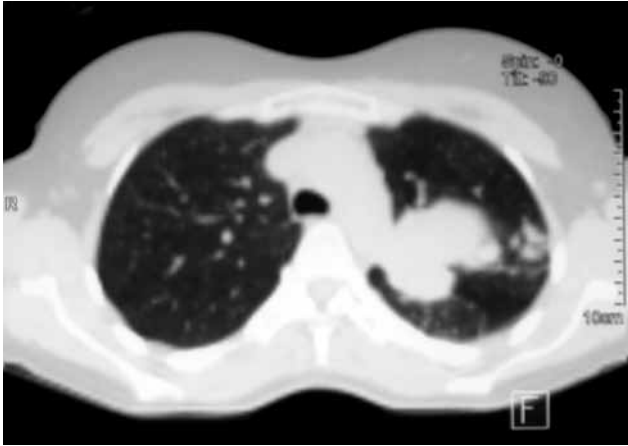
Chest computed tomography shows an irregularly circumscribed, lobulated large tumor in the left side of the parahilar region.
